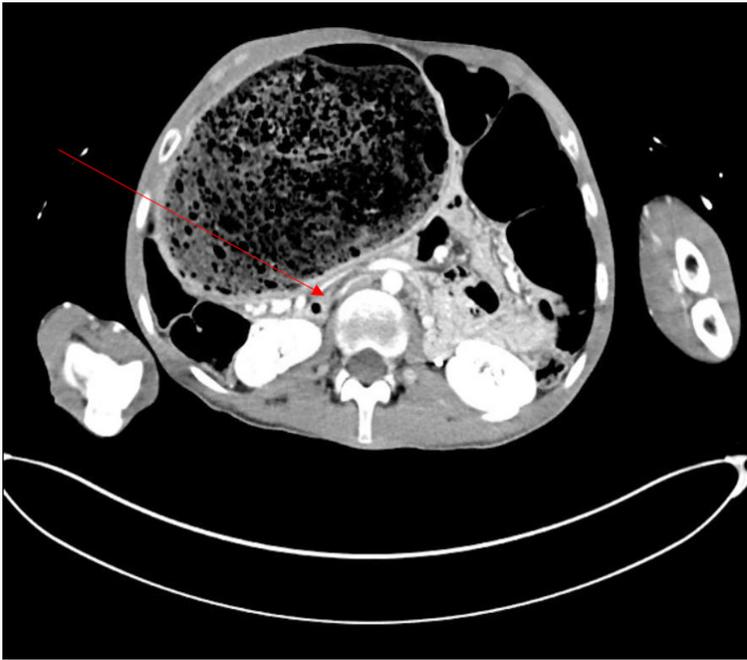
Computed tomography of abdomen and pelvis with contrast showing dilated sigmoid colon with hyperdense mass with air foci, demonstrating a 47x15.6x12cm fecaloma, with compression of the IVC (red arrow).
